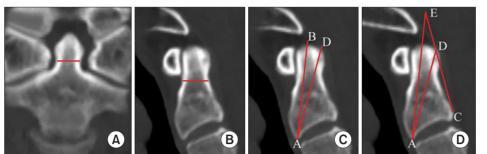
Odontoid process parameters in computed tomography images. (A) Minimum external transverse diameter of the odontoid process on the coronal view. (B) Minimum external anterior-posterior diameter. (C) Screw length toward the posterior odontoid tip (AD). (D) Screw projection back angle at point E and point D.
